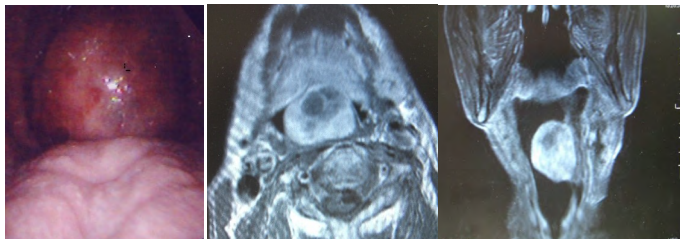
Oral findings (Left) and MRI (Middle axial, Right Coronal) showed a mass occupying most of the oropharynx.
